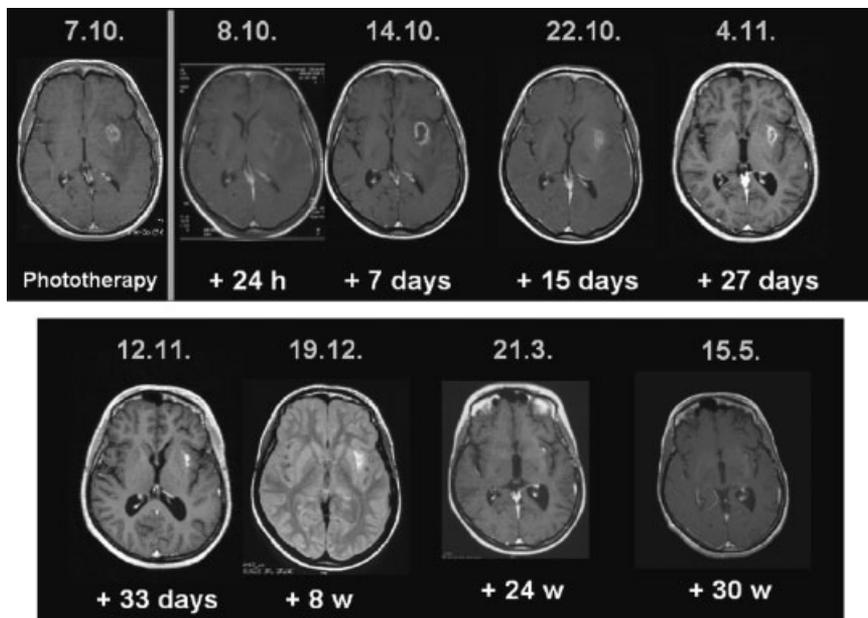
Series of contrast-enhanced MRI-scans (T1 weighted) of a patient treated with iPDT.
